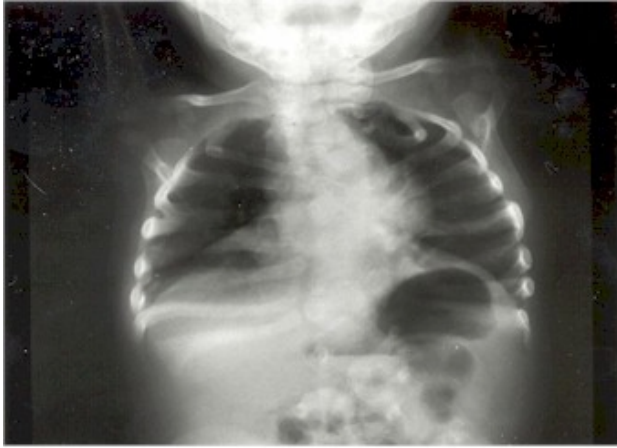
Chest anteroposterior roentgenogram of Case 1.
